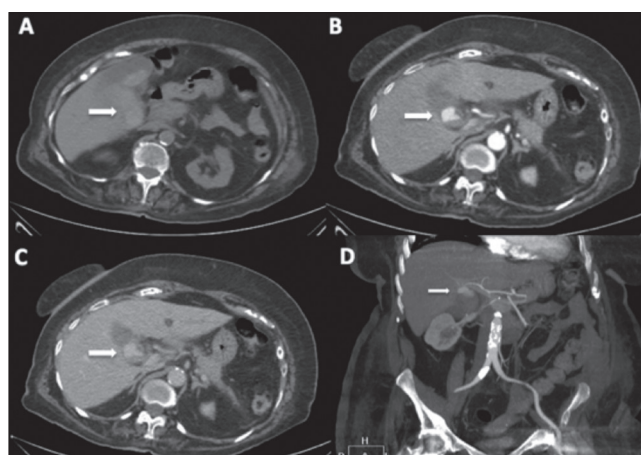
A. Axial section of an abdominal CT which showed a hyperdense content within the gallbladder (arrow). B. A rounded structure which is enhanced like the vessels (arrow) was observed in the arterial phase of the study. C. The venous phase continued showing the rounded structure (arrow). D. Coronal section of a MIP (maximum intensity projection) reconstruction where a rounded structure (arrow) could be observed, in relation with hemobilia related to the right hepatic artery branch, probably the cystic artery.
